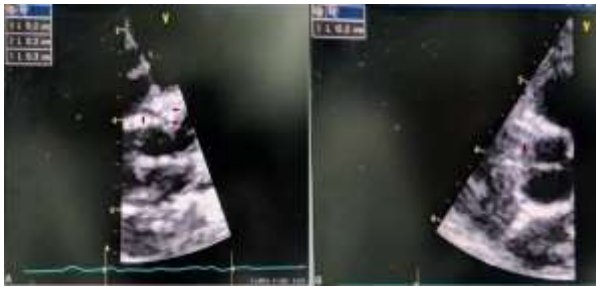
Parasternal short-axis (PSAX) view showing proximal diameter of coronary arteries (left main coronary artery, left anterior descending artery, circumflex artery) (A); right coronary artery (B)
